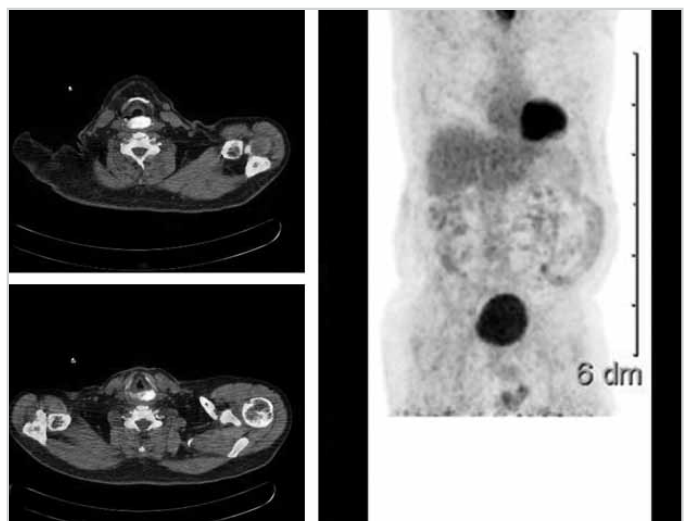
PET -CT images of patient with the vegetative tumor on the hypopharynx, distant metastases could not be seen
